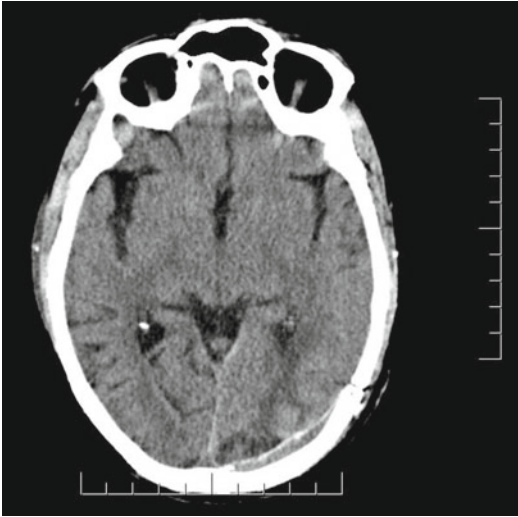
Relapse of myeloma with an extramedullary plasmacytoma of the brain, with a left parietal-occipital mass on CT scan (a) and MR scan (b, T1 imaging). Mixed
